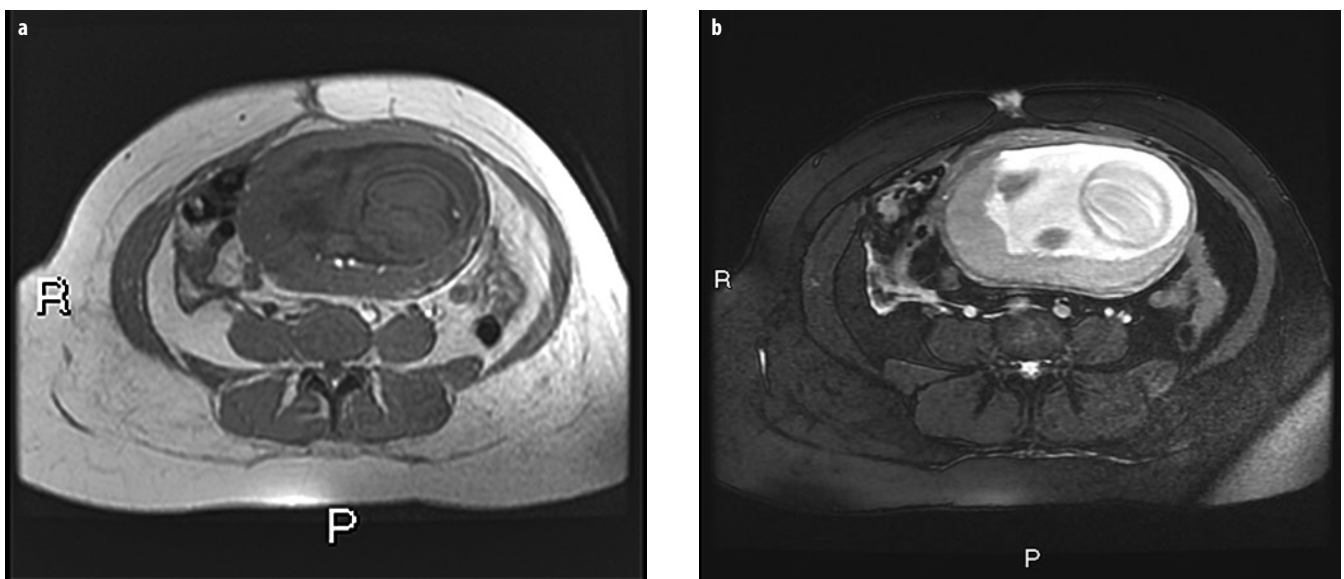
a, b. A 30-year-old patient, 22 weeks pregnant, with right lower quadrant pain, vomiting, and elevated white blood cell count due to appendicitis, as demonstrated on magnetic resonance imaging (MRI). a Axial T1-weighted gradient-recalled-echo (GRE) image through the lower abdomen shows an 11-mm appendix extending posteriorly from the cecum, with inflammatory changes surrounding the more distal appendix, including fascial thickening. b Axial T2-weighted GRE image at the same level demonstrates the same finding. The appendix was correctly identified as being perforated on the prospective interpretation of this MRI examination, as proven at subsequent emergency surgery
